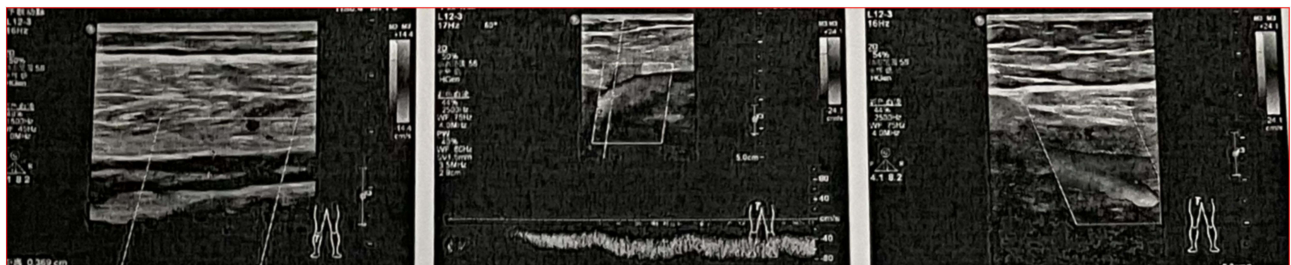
Venous ultrasound images showed the intermuscular vein thrombosis in the left calf (A) and peroneal vein thrombosis in the right calf of one representative patient in the Device group 2 days after surgery. The left (A) and right (B) lower limb vein trunk were displayed, and there is no obvious abnormality in the course. (A): Several slightly dilated veins can be seen in the left calf, which are filled with low echoes. The lumen was not deformed greatly when the probe was compressed, and no obvious blood flow signal was seen inside. (B): The lumen of some segments of the peroneal vein is slightly dilated, filled with low echoes, and was 3.7 mm wide. CDFI: No obvious blood flow signal was seen. No obvious solid echo is seen in the lumen of the remaining right lower limb vein trunks, and the lumen can be closed by probe pressure. No obvious solid echo was found in the lumen of the remaining left (A) and right (B) lower limb vein trunk, and the lumen can be closed when the probe is compressed. CDFI+ PW in both A and (B) The blood flow signal was well-filled; there was no obvious abnormality in the direction and speed of blood flow in a stable condition. No thrombi were found in the deep and superficial veins in the left and right thigh (A and B).
